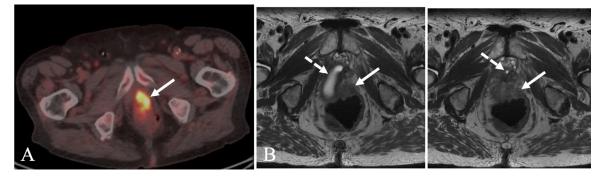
(A) Fused ¹⁸F-fluciclovine positron emission tomography (PET)/computed tomography (CT) scan showing a large PET avid mass in the prostate fossa (white arrow). (B) This mass (solid arrows) sits adjacent to the neobladder and the anastomosis with the urethra (dashed arrows).
